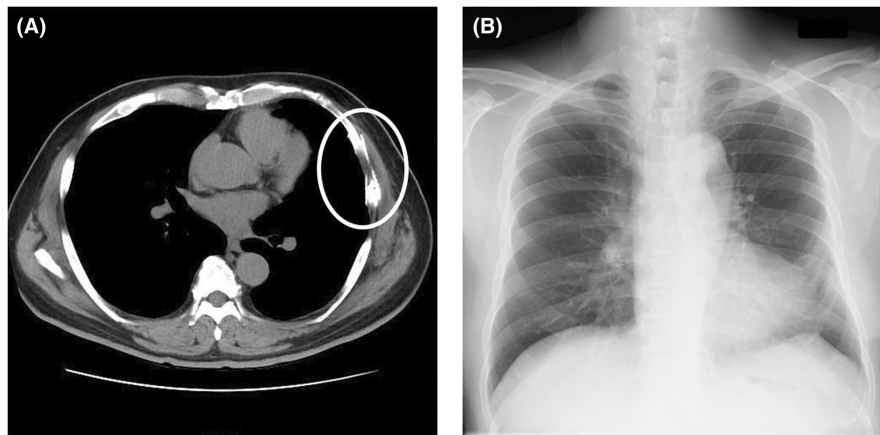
Computed tomography and chest radiographic images 3 months postoperatively. The computed tomography and chest radiographic images obtained 3 months postoperatively show no existing injuries. (A) The left fifth and sixth ribs are sandwiched between the artificial plates (encircle), and no ventricular aneurysm is observed. (B) The left fourth to seventh rib fractures are repaired, and the left diaphragm remains unelevated.
